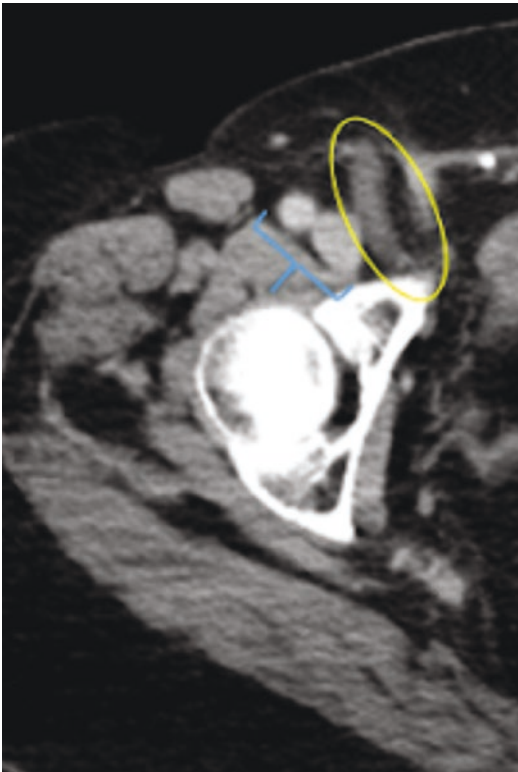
CT pelvis with intravenous contrast to highlight vessels. Mesh plug (circle) placed in the femoral space adjacent to the femoral vessels (bracket). Patient had chronic pain resolved by surgical removal of the plug
